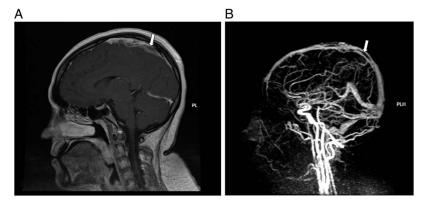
(A) Brain MRI with contrast and (B) MRV (both sagittal views): extension of the thrombus noted in the superior sagittal sinus (arrow).
